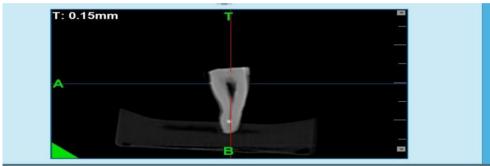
CBCT evaluation of teeth in which gutta percha has been removed using EdgeEndo XR file system
